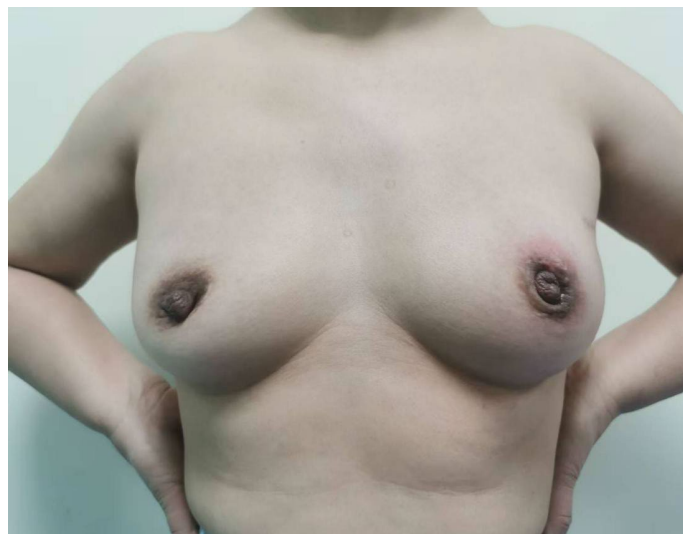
Catheter drainage under color Doppler ultrasound guidance combined with prednisone treatment (before).
